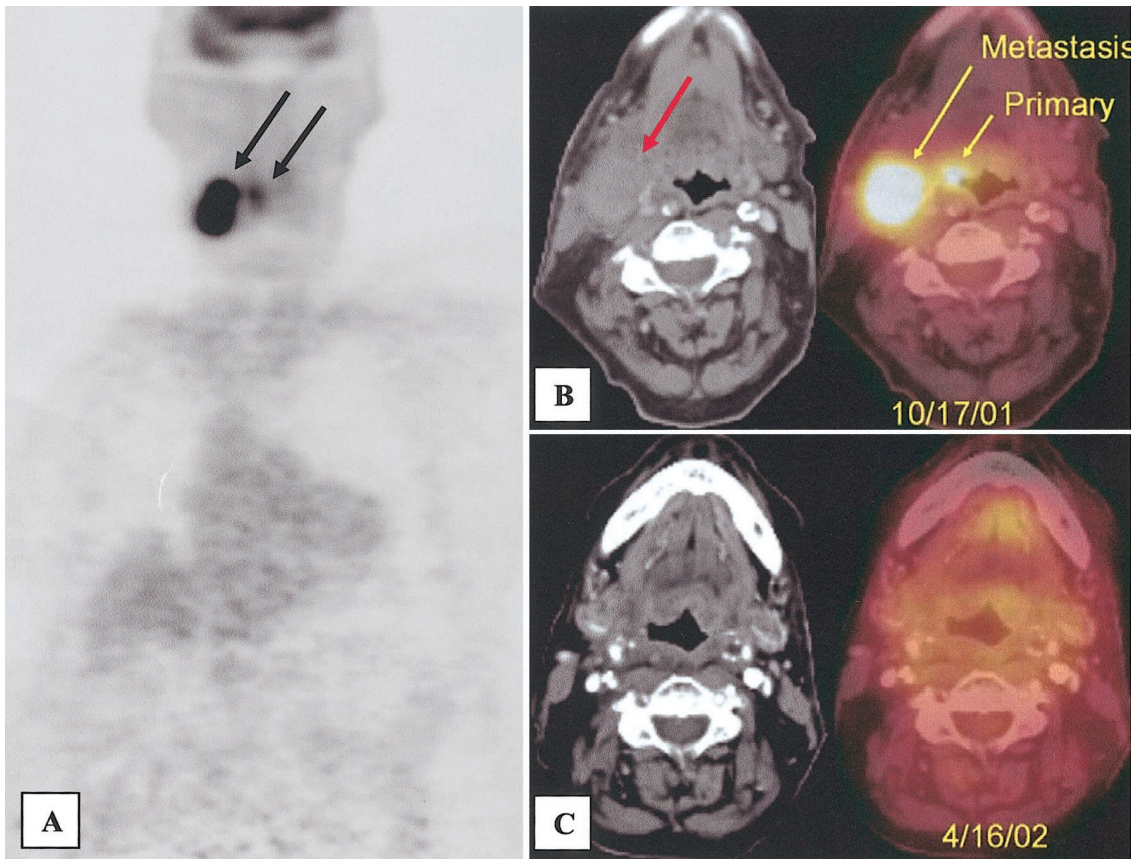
(A) Coronal PET. (B) Pre-surgical axial CT and PET/CT images. (C) Post-surgical axial CT and PET/CT. This patient was diagnosed with metastatic squamous cell carcinoma of the head and neck by fine needle biopsy of a large right neck mass. CT (not shown) prior to combined PET/CT could not identify a mucosal primary. Coronal PET shows intense uptake in a large right neck mass with an adjacent focus of uptake (black arrows). Pre-surgical CT shows the large mass (red arrow) but does not show the mucosal primary (small yellow arrow). Only the fused image demonstrates the exact location of the mucosal primary. Follow-up images after surgery and radiation demonstrate no evidence for recurrence.
